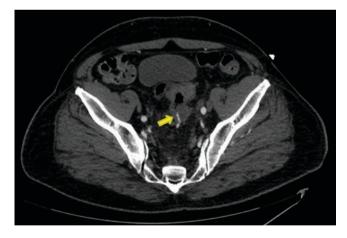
Computed tomography image demonstrating active extravasation from the inferior mesenteric artery (arrow) into a necrotic rectosigmoid tumor causing significant intraluminal bleeding requiring resection
